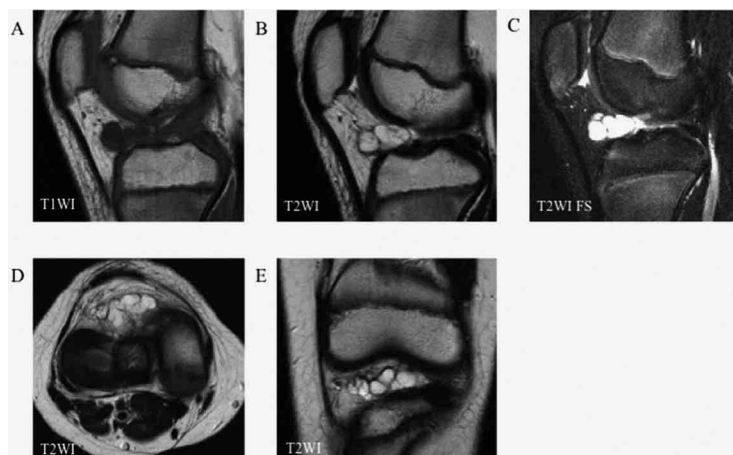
Preoperative magnetic resonance imaging (MRI) findings. A multilobular cystic lesion with a thin membrane is apparent between the infrapatellar fat pad and anterior cruciate ligament. The well-circumscribed mass shows low-intensity on T1-weighted imaging (T1WI) (A) and high or iso-intensity on T2-weighted (T2WI) and fat-suppressed T2-weighted images (T2WI FS) (B-E).
